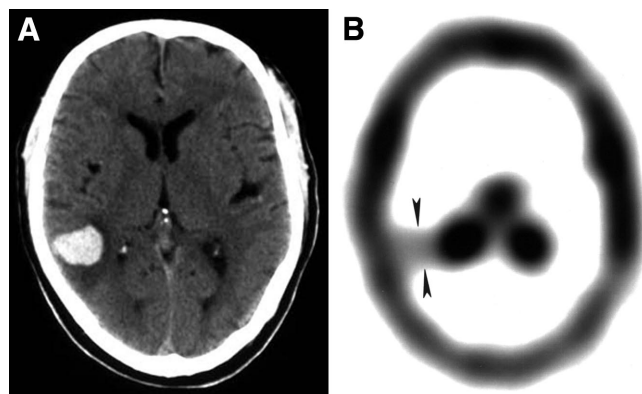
Patient 17, a 55-y-old man with sudden onset of cephalalgia. (A) Emergency CT scan shows atypically located 25-mm large, round hematoma in right paratrigonal region. Lesion is surrounded by moderate edema. (B) ^{99m}Tc -MIBI SPECT image obtained at 10 d shows homogeneous focal area of ^{99m}Tc -MIBI uptake (arrowheads) (^{99m}Tc -MIBI index = 1.33).
